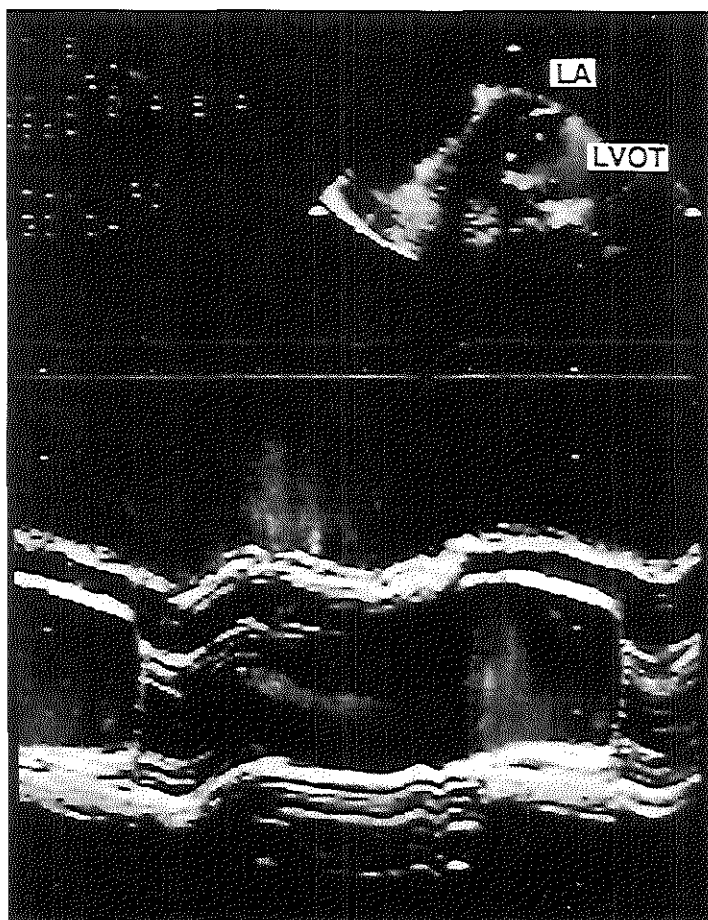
Case 15. Transoesophageal colour flow map (top) and colour M-mode study (bottom) in the immediate evaluation of balloon aortic valvuloplasty. From a high oesophageal position, the left ventricular outflow tract (LVOT) is visualized anterior to the left atrium (LA). The M-mode line is positioned at the level of the aortic valve. The absence of systolic turbulence across the aortic valve indicates successful gradient relief. Trivial central aortic regurgitation is noted during diastole.
